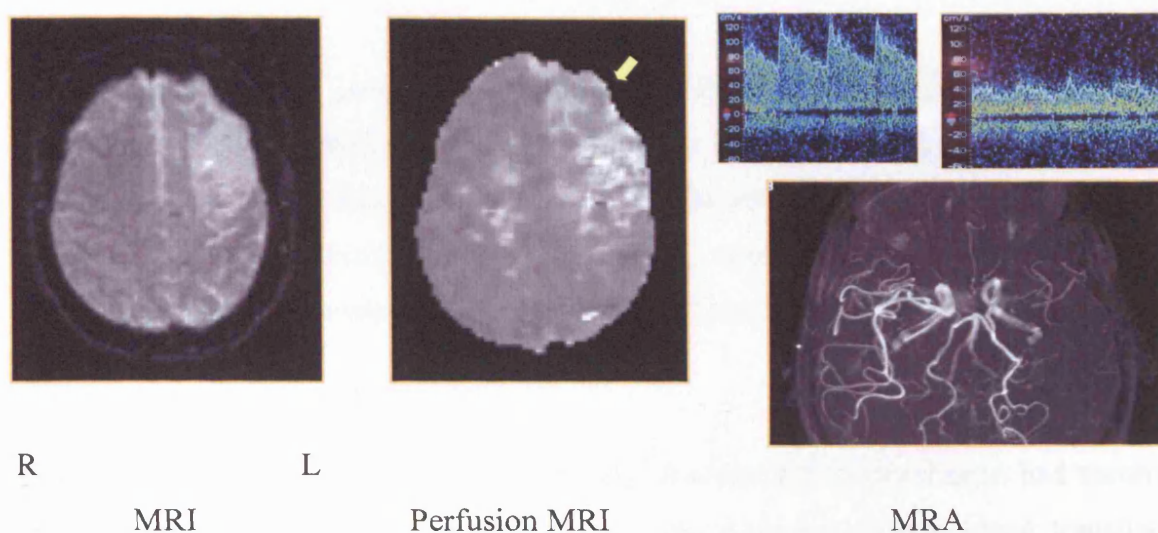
Short-term blood transfusion (same patient). *Post-Blood transfusion (six days post-transfusion).* T2-w MRI. Unchanged MRI. Improved Perfusion MRI. Decreased (compared to pre-transfusion) mean transit time of the passage of IV contrast bolus (and increased cerebral blood flow) in the left frontal region and, in some degree, in the left MCA territory. MRA. Unchanged for the left MCA & ACA. Slight improvement in the visibility of distal vessels. TCD: slight increased of the left MCA blood flow velocities and less turbulent flow in the left ACA. R: right; L: left.
